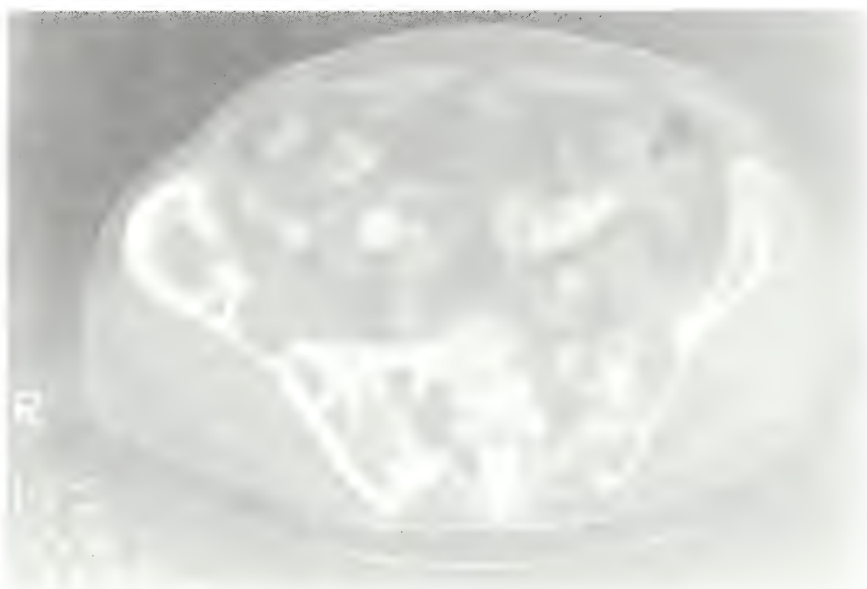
CT through the ilium at S-1 level demonstrates myelomatous masses with destruction of the bony cortex and invasion of the medullary cavity, 1985.
